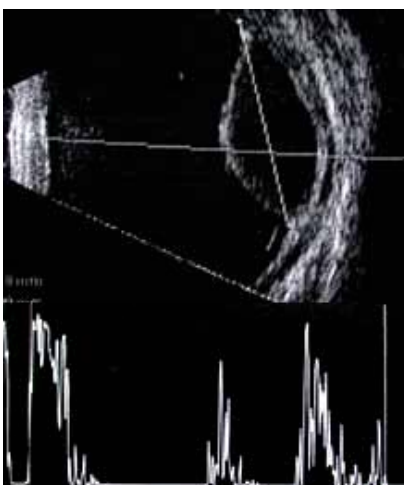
Ultrasound of tubercular choroidal granuloma.
